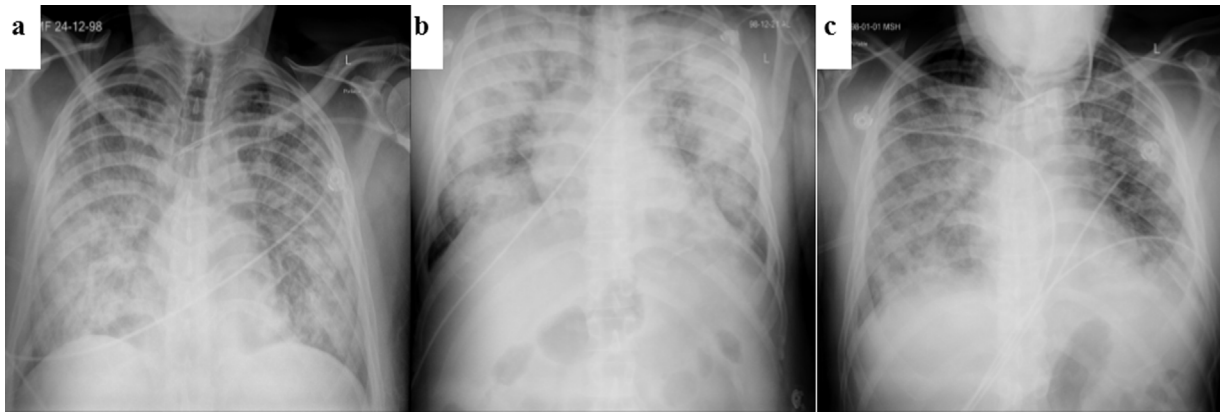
The chest X-ray of the patient during hospitalization (a; admission time, b; before hemoperfusion, c; after hemoperfusion).
